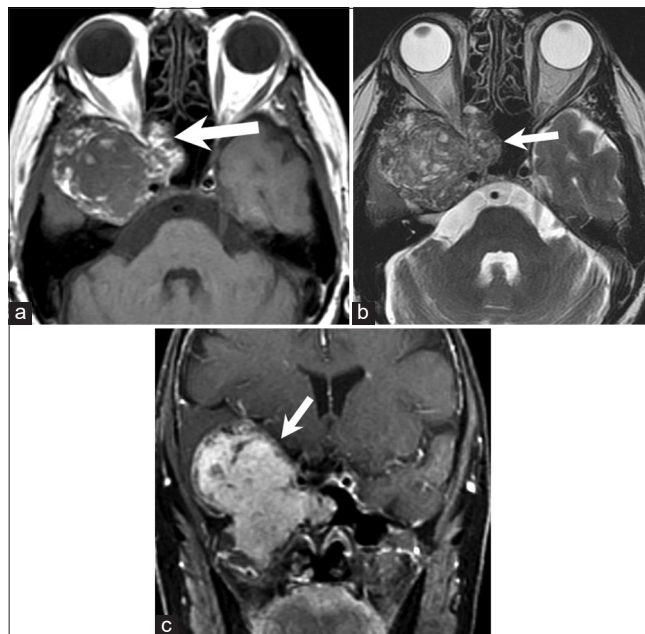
Chondromyxoid fibroma. A 56-year-old woman with chondromyxoid fibroma of the right central skull base presenting with multiple right cranial neuropathy. Axial T1WI (a), axial T2WI (b) and coronal contrast-enhanced T1W MRI image with fat suppression (c) show a large expansile mass arising from the right greater wing of sphenoid (arrows). The tumor demonstrates mixed signal intensity on both T1WI and T2WI with small lobular foci of T2 hyperintensity, and diffuse contrast enhancement.
